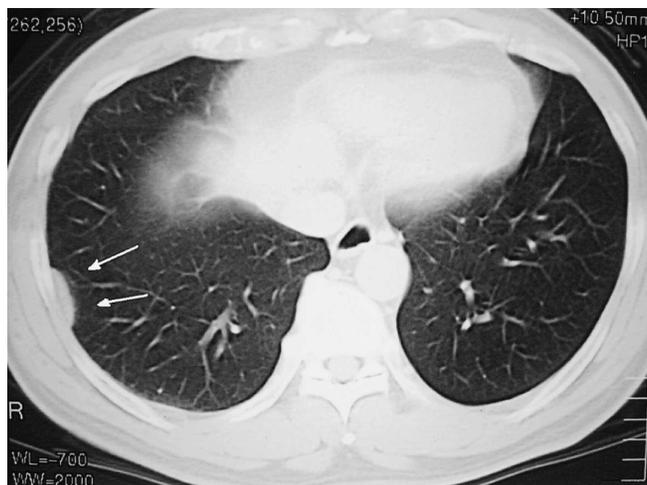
Chest CT scan showing a region of homogeneous density in the right chest wall smoothly outlined by extrapleural signs.
